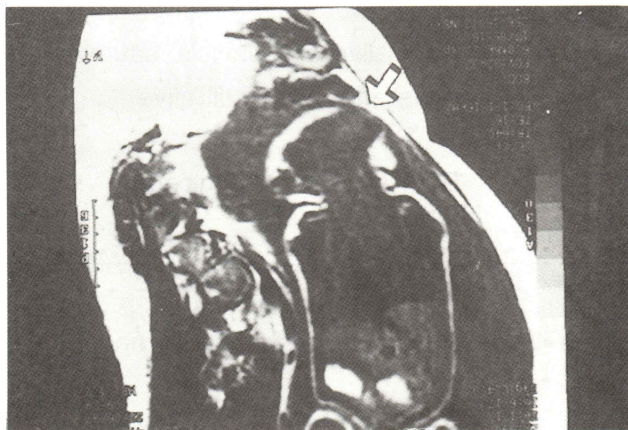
MRI image of microcephaly with encephalocele.
